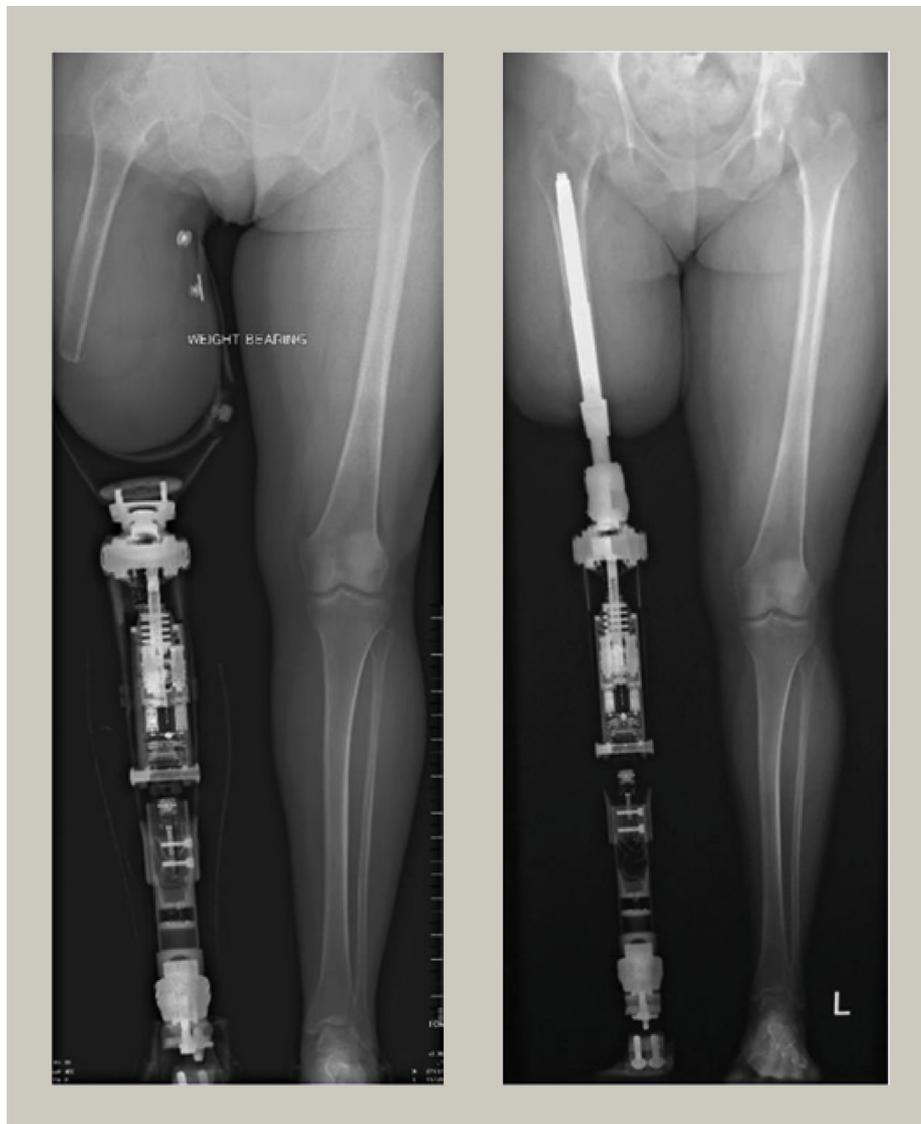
Transfemoral amputee before and after insertion of an OPL implant into the residuum of her right femur. The x-rays clearly show the improvement in the alignment of the residual femur with the bone-anchor in place. (Images courtesy of Professor Munjed Al-Muderis.)
